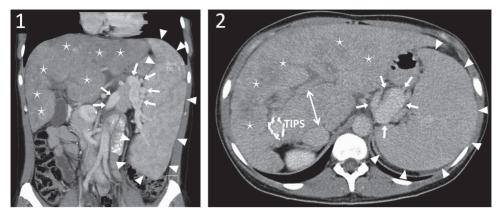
Computed tomography (CT) in portal venous phase of a 32-years-old female patient with Budd-Chiari syndrome, who developed liver cirrhosis, portal hypertension, and splenomegaly showing macronodular regeneration in the liver parenchyma that has mottled appearance (asterisks), an enlarged caudate lobe (two-headed arrow), dilated splenic vein with conspicuous collateral veins (arrows), and enlarged spleen (arrowheads) in coronal (1) and axial (2) plane. This patient received a transjugular portosystemic shunt (TIPS) in order to reduce porto-systemic gradient and the risk of variceal bleeding.
